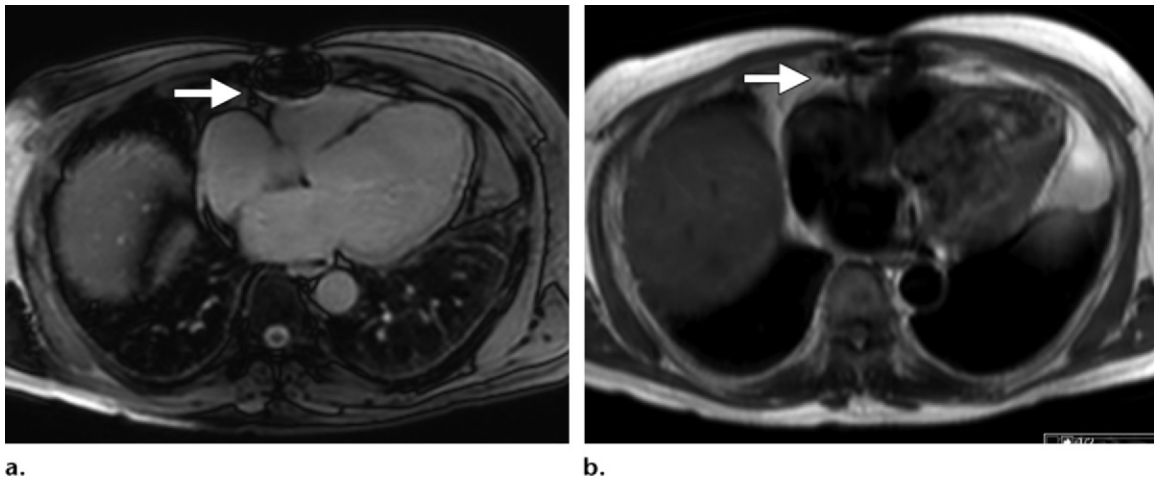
Susceptibility artifacts. (a) SSFP MR image at 3 T shows a prominent susceptibility artifact from a median sternotomy wire (arrow). (b) Half-Fourier acquisition single-shot turbo spin-echo (HASTE; Siemens Healthcare, Erlangen, Germany) MR image shows that the same artifact is less prominent (arrow).
